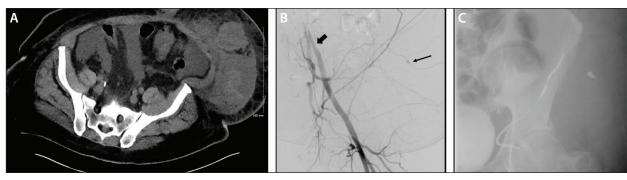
A man in his mid 60s presented with decompensated cirrhosis with abdominal wall pain and swelling associated with a 4-g hemoglobin drop (10 to 6 g) and new tachycardia after paracentesis. Two units of packed red blood cells (PRBCs) were given and interventional radiology consulted. CT without contrast (acute kidney injury on stage 4a chronic kidney disease) demonstrating a left abdominal wall hematoma with mixed density, suggesting acute hemorrhage (A). Digital subtraction angiography (DSA) of the external iliac artery with a 5-F Vert catheter (thick arrow) via right radial access demonstrating a pseudoaneurysm from the branch of the left inferior epigastric artery (thin arrow) (B). Coil embolization across the culprit branch containing the pseudoaneurysm (C). Hemoglobin stabilized postprocedure without further transfusion.
